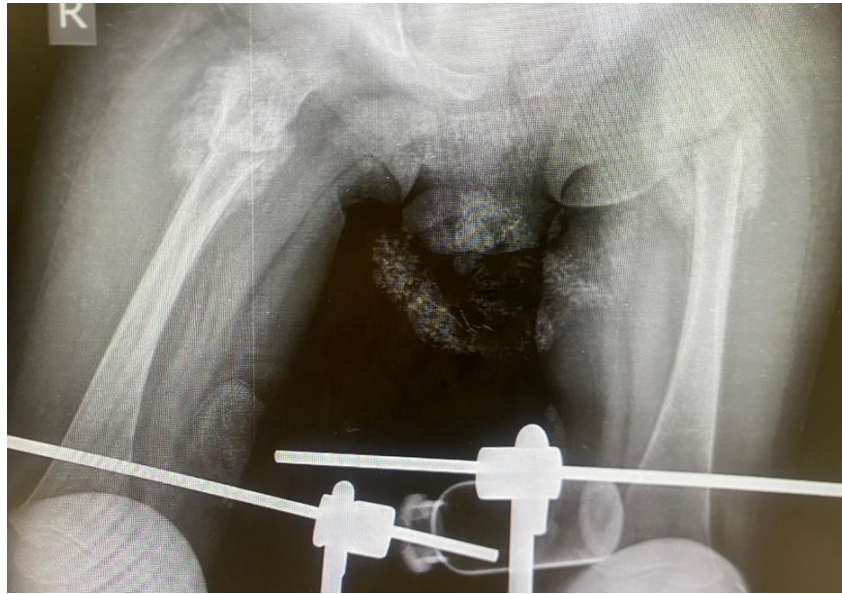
Post-treatment ap radiograph after 14 days from trauma. (Prepared by Authors, 2026).
